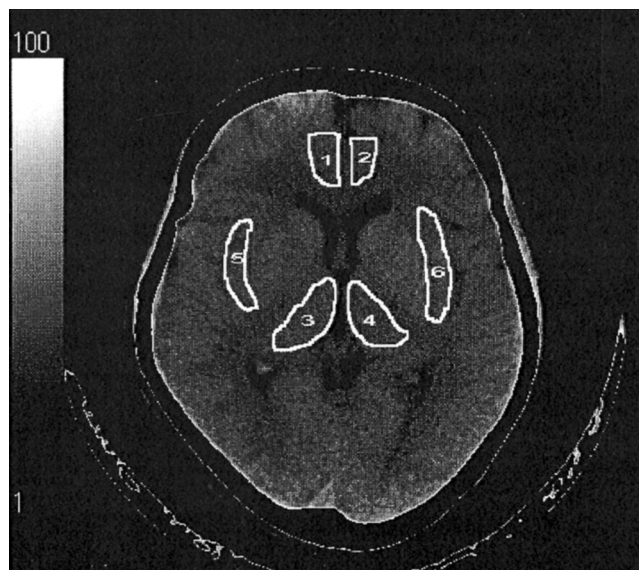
Xenon-CT section for rCBF measurement 7 days after ECT. The xenon transverse CT slice was taken 5 cm above the orbitomeatal line (OM line) at the level of basal ganglia. The right (1) and left (2) subgeniulate part of the anterior cingulate cortex (Brodmann's areas 32), right (3) and left (4) thalamus, and right (5) and left (6) insula
